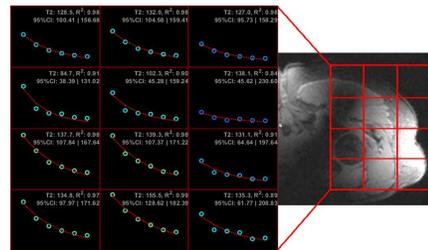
(A.) *In vivo* T_2 measurement of PCr located in the gluteal muscles as annotated by the red grid in (B.) the T1-weighted localizer image. Maximum peak values are denoted as open circles and the fit is represented as a red dotted line.
